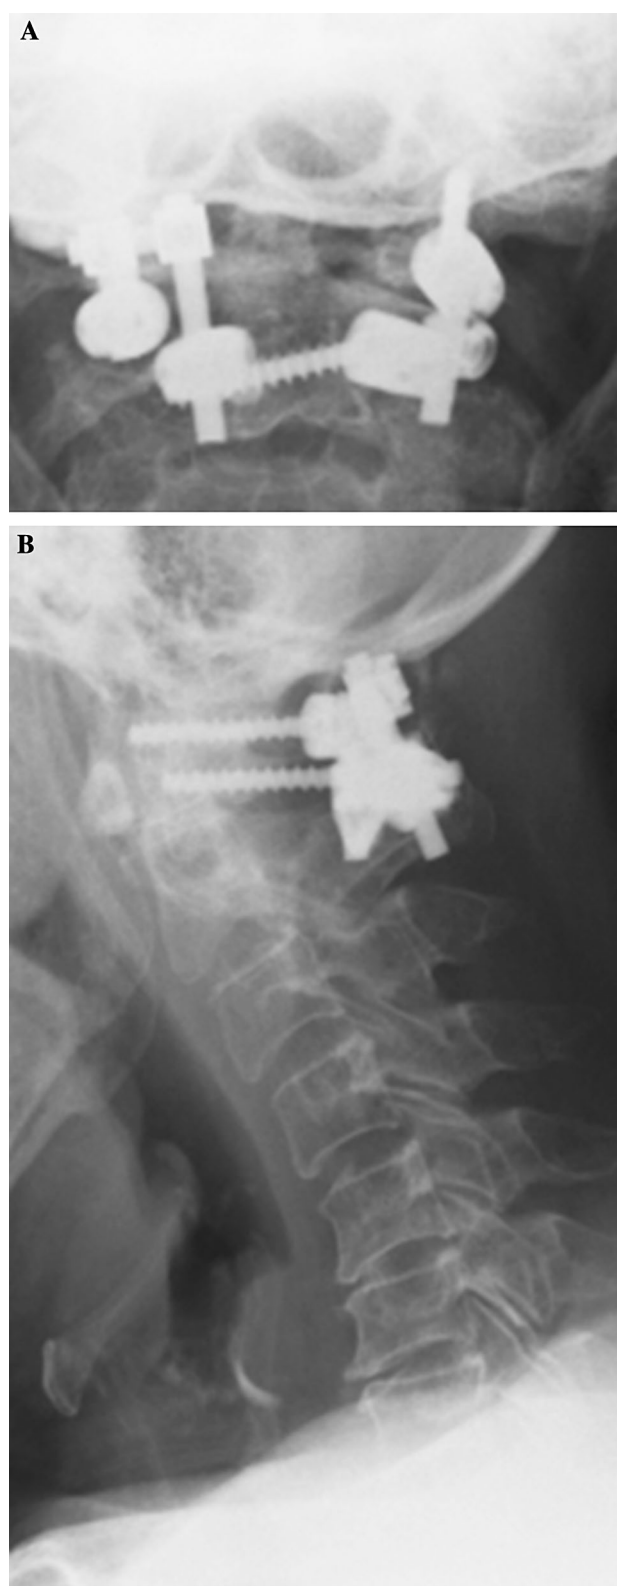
Plain X-ray image after posterior fusion surgery for C1 and C2. A lamina screw and hook were used for C2, fixed with lateral mass screws in C1. a Anterolateral view. b Lateral view
